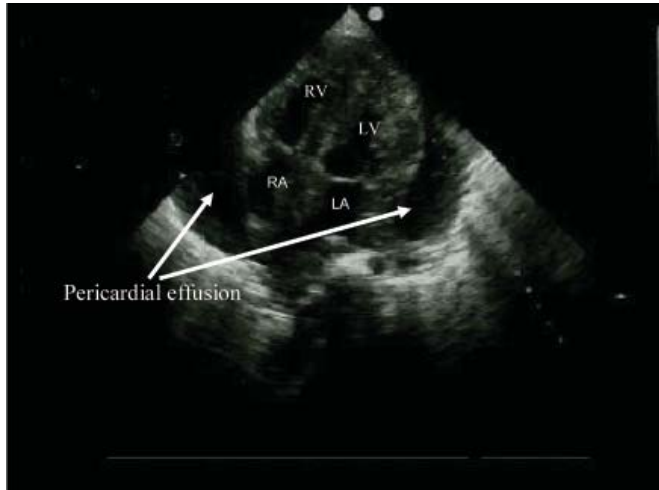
Echocardiography of the pregnant woman with SLE complicated by pericardial effusion.
